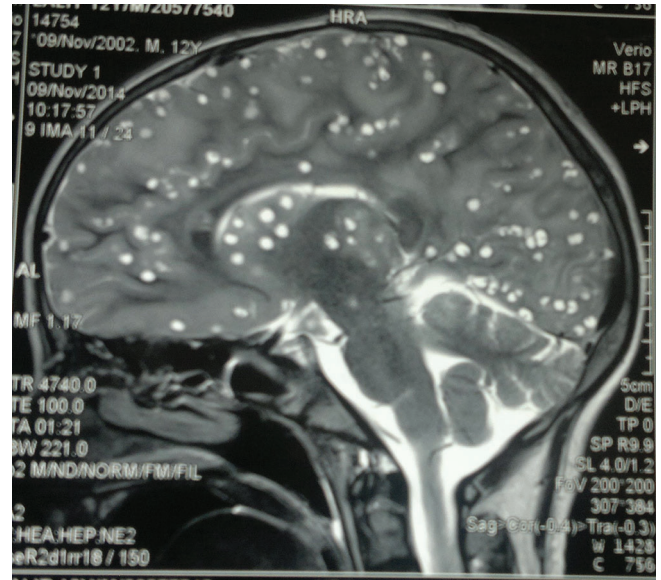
MRI brain showing multiple solid and cystic lesion appearing hyperintense on T2 W image giving the characteristic “Starry sky appearance”.
